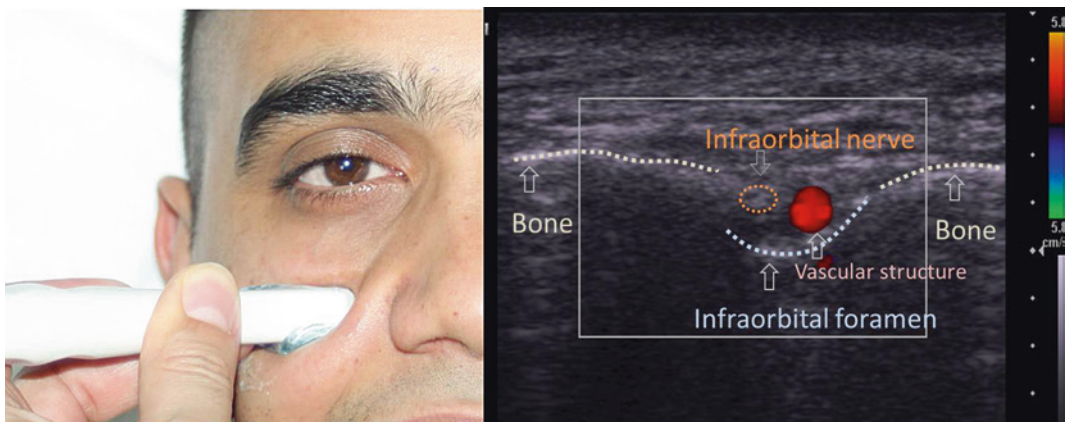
Ultrasound image for infraorbital nerve block
